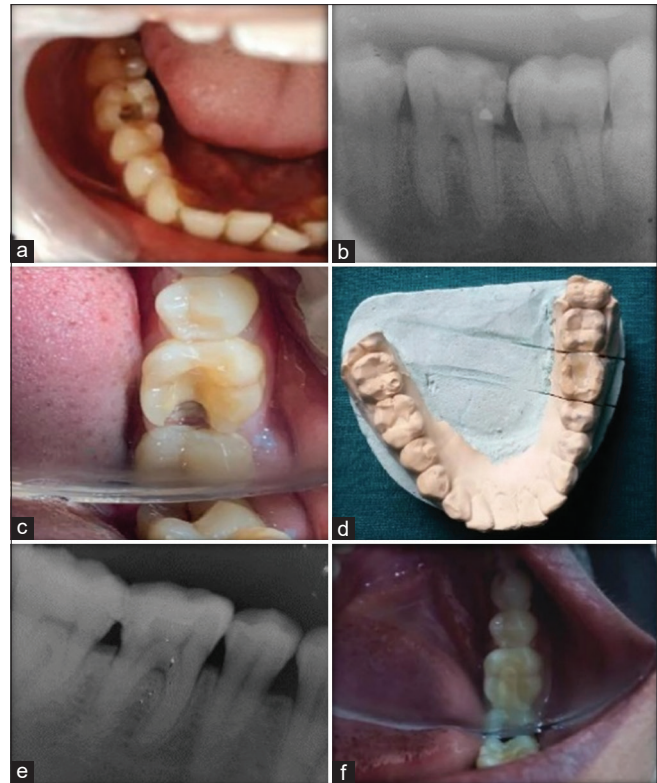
(a) Pre-operative picture (b) pre-operative radiograph (c) cavity preparation (d) cast (e) post-operative radiograph (f) post-operative picture
